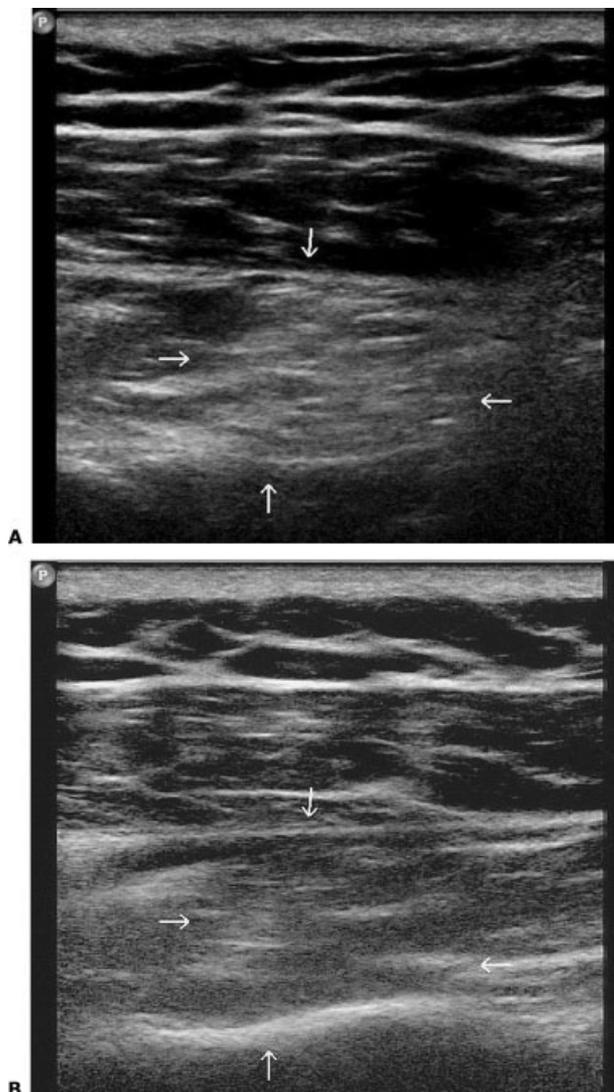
(A) Transverse sonogram of right teres minor muscle (arrows) shows increased muscle echogenicity with slight loss of muscle bulk. The overlying deltoid muscle has a normal sonographic appearance. (B) Transverse sonogram of the normal left teres minor muscle (arrows) is shown for comparison.
